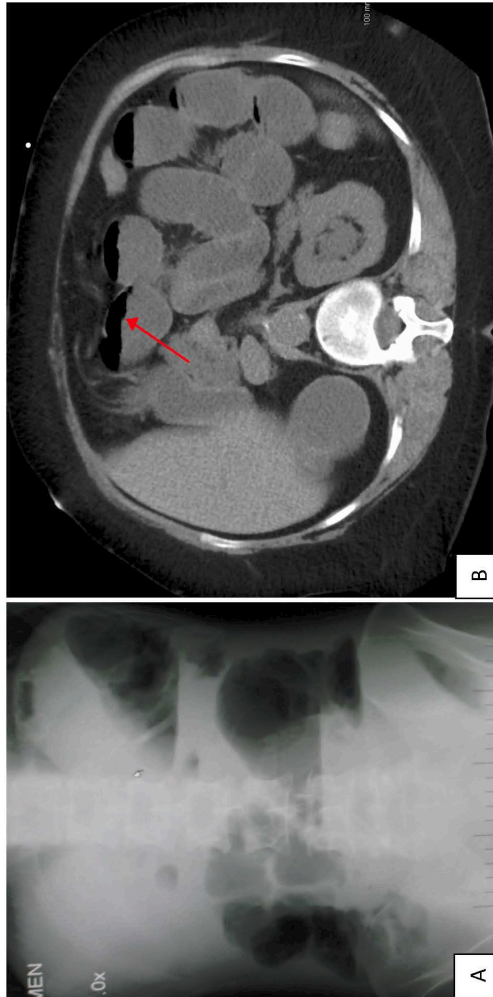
A) Abdominal radiograph demonstrating small bowel obstruction (Heilman 1a, n.d); B) Axial image of a computerised tomography scan demonstrating small bowel obstruction. The red arrow indicates the air/fluid level typical of bowel obstruction (Heilman 1b).*
